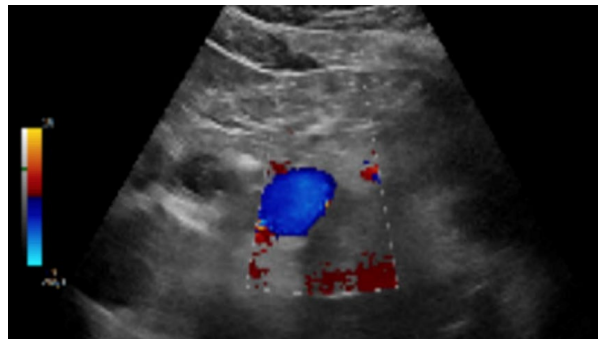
Ultrasound of left adrenal gland mass measured roughly 15.4 x 11.8 x 14 cm.
